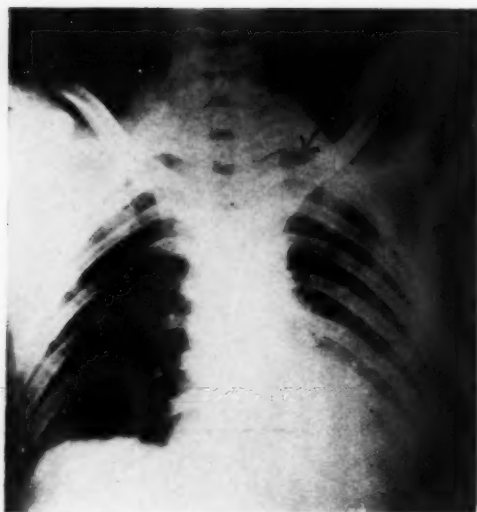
Case III. Portable film obtained four days after automobile accident and evacuation of subdural hematoma, three days after hematemesis. Small amount of left pleural effusion. The patient was in shock. Rupture of the esophagus was suggested by the X-Ray Department.
